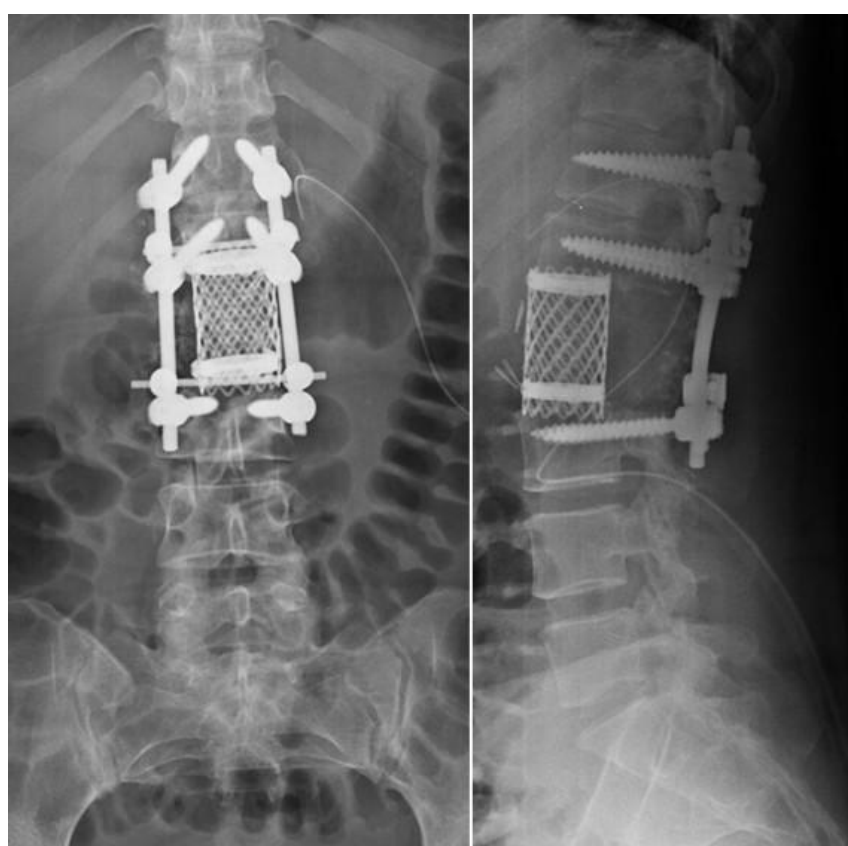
Postoperative x-rays showed the L2 spondylectomy and 360° T12-L3 instrumented arthrodesis.
